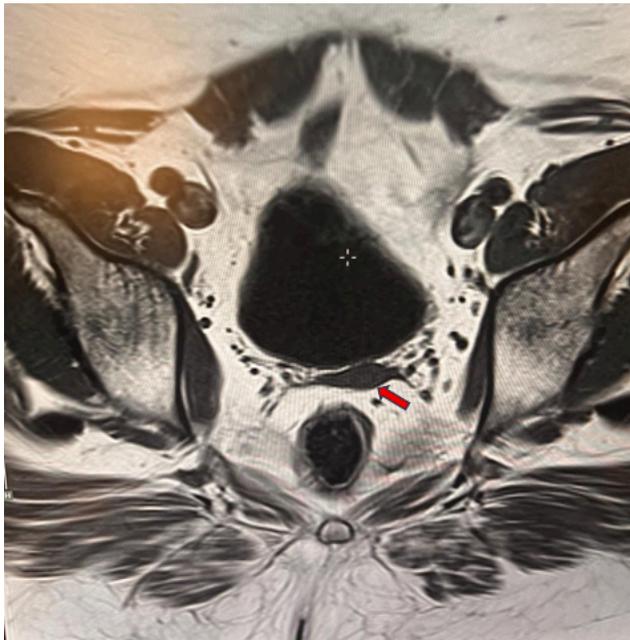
MRI pelvis of a 24-year-old female showing hypoplastic uterus (arrow) with absent both ovaries
